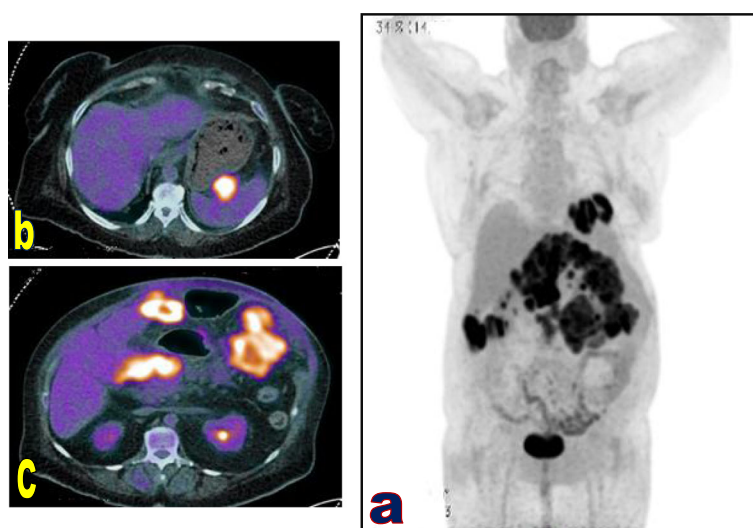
3D MIP (a) and axial fused PET/CT images (b and c) for a 70-year-old female patient with history of gastric cancer underwent surgical excision. Operative bed is clear. Hypermetabolic peritoneal nodules, masses, and sheet-like infiltrates seen beneath the abdominal wall, in the mesentery, hepatic, and splenic reflections. The largest seen in the left hypochondrium related to hepatic surface at segment III. Final diagnosis obtained by radiological follow-up for peritoneal metastasis
